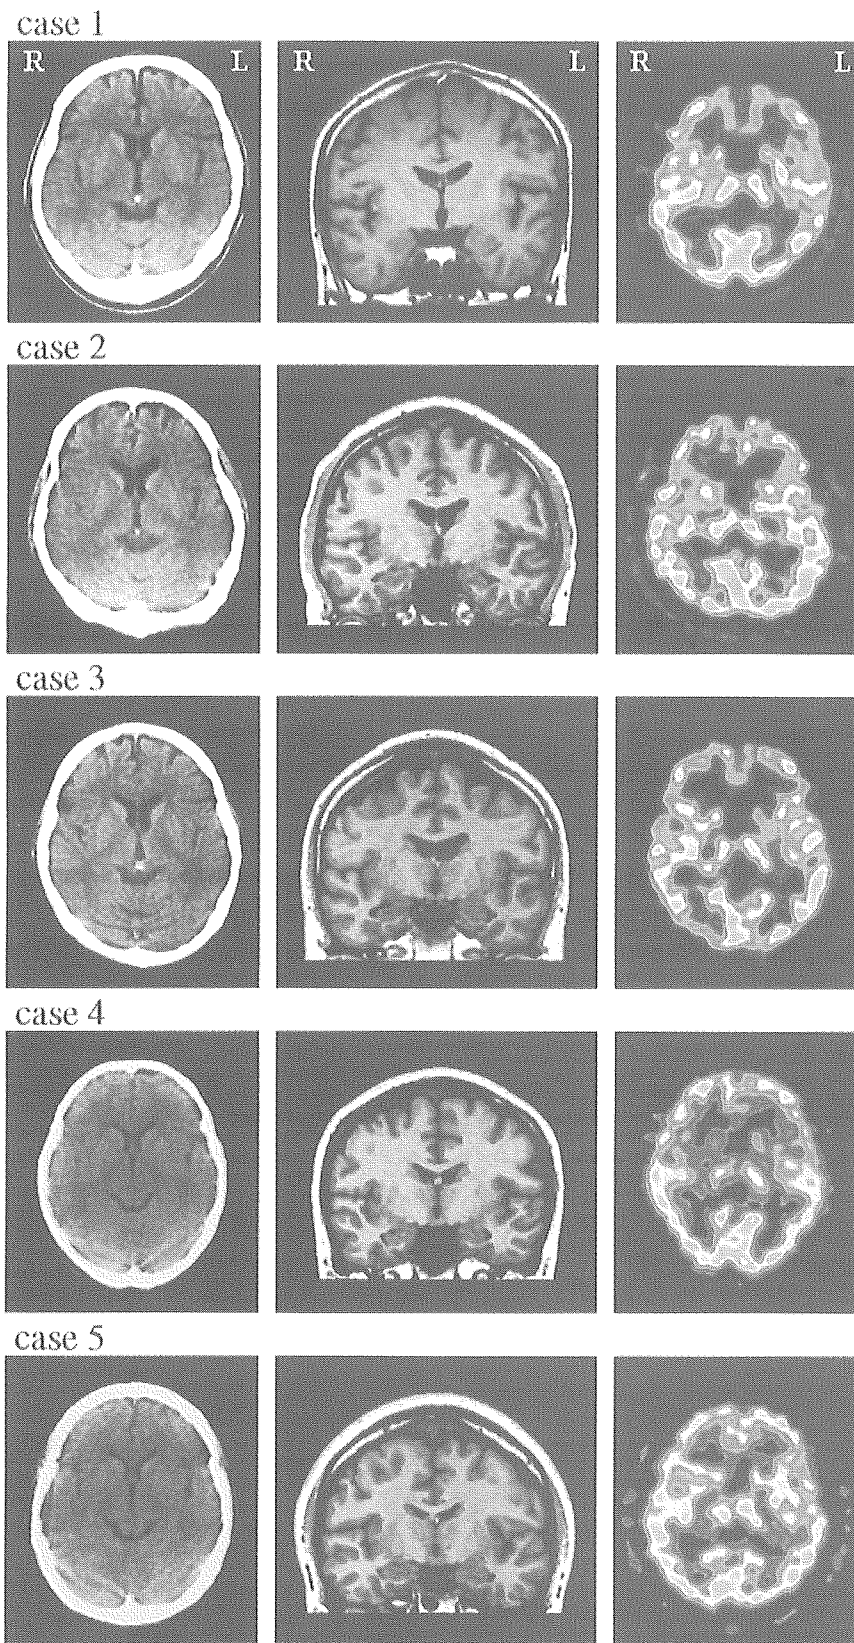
Computed tomography images (left column), T1-weighted coronal magnetic resonance images through the mammillary body (middle column), and single photon emission computed tomography images (right column) in each patient with simple schizophrenia. Findings are described in the text.
